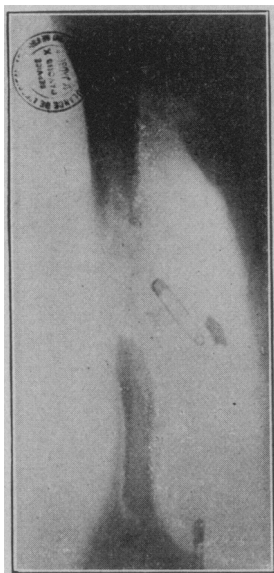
Compound infected fracture of humerus, shell wound. Course complicated by typhoid fever. Drainage of upper fragment good. Large sequestrum of lower fragment, the result of insufficient drainage. Roentgenogram ten weeks after injury.
